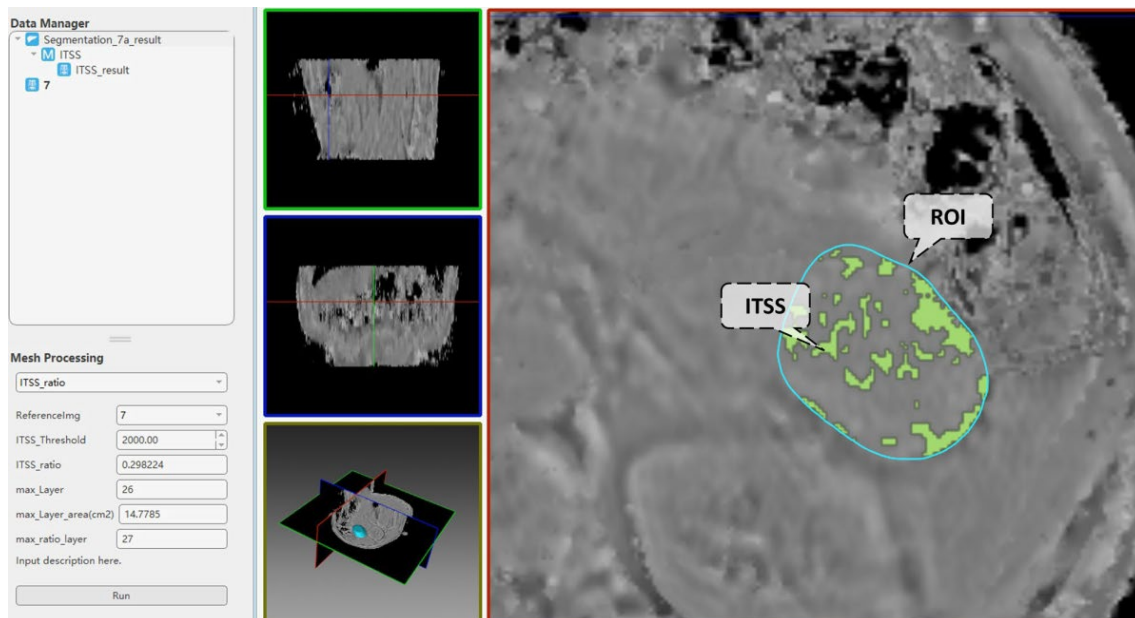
An example of a user-defined extension module for target analysis in MR images
